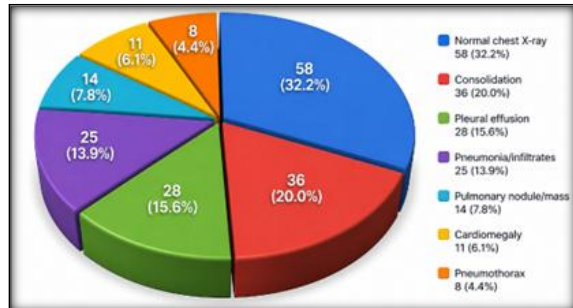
Distribution of Chest X-ray Findings Among the Study Participants
